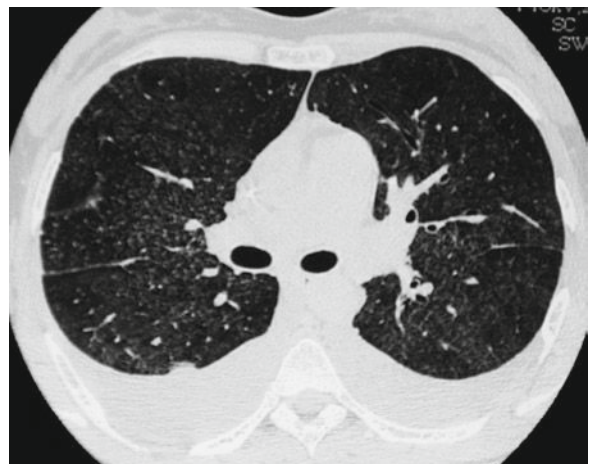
High-resolution computed tomography (HRCT) revealing diffuse ground-glass opacities and bilateral pleural effusion
